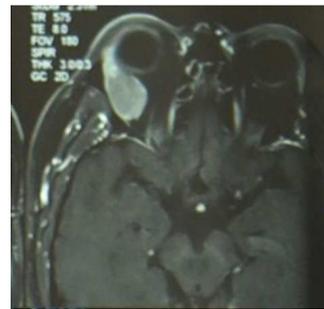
MRI: Lacrimal gland neoplasm.
